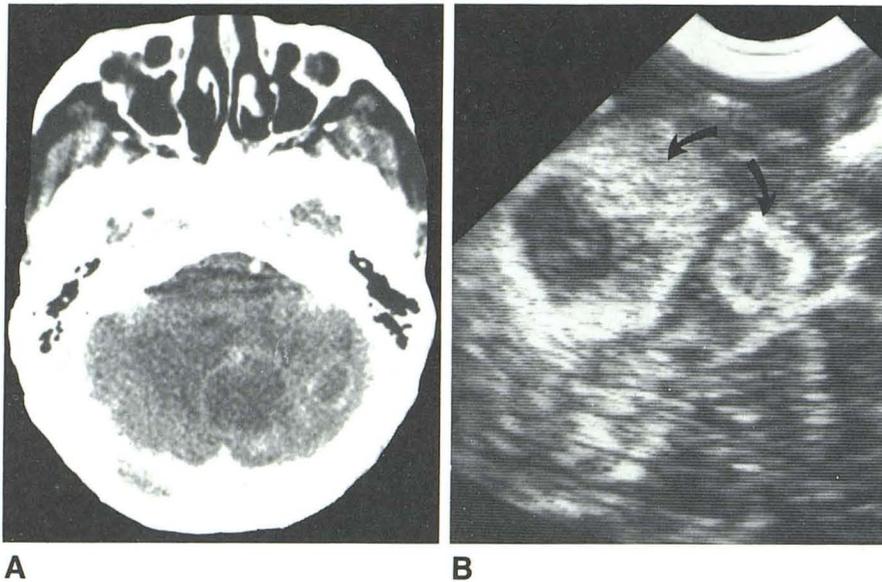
A, Contrast-enhanced CT scan. Two cerebellar metastases. B, Intraoperative sonogram delineates two solid lesions (arrows) with hypochoic centers. Pathologic examination revealed adenocarcinoma.
